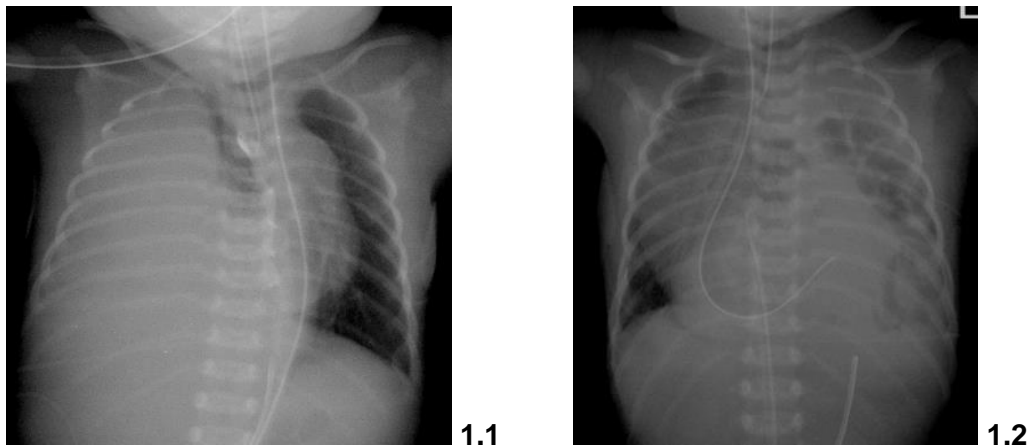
plane chest X-ray of neonates: 1.1 right-sided CDH: opacity of right hemithorax, mediastinal shift to the left; 1.2 left-sided CDH: insuflated bowel-loops in left hemithorax, stomach-up (nasogastric tube), mediastinal shift to the right
